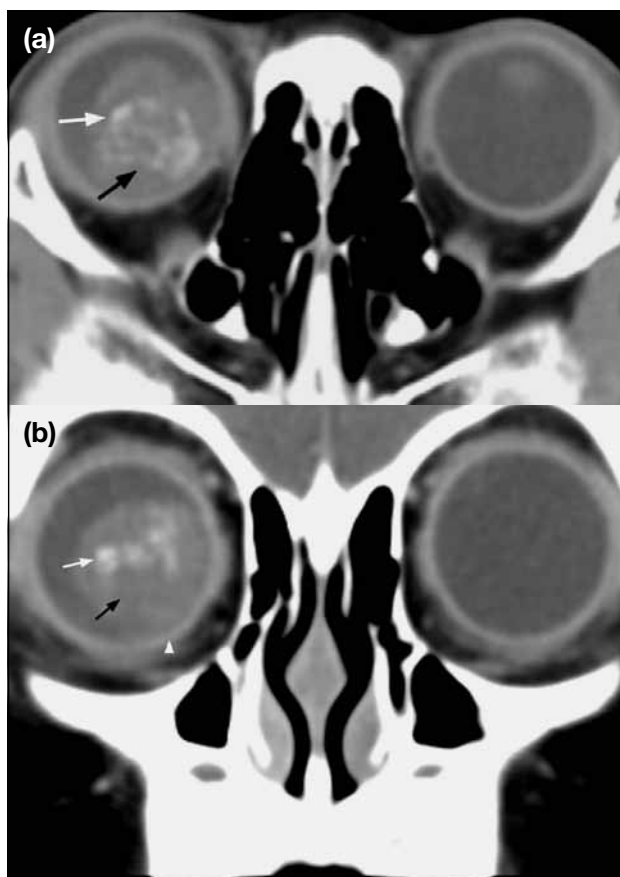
Computed tomographic orbit of a 2-year-old girl with proven retinoblastoma. (a) Axial image: calcified lesion (white arrow) with mass-like enhancement (black arrow). (b) Coronal image: comparable volumes of both affected (white arrowhead) and non-affected globes. Notably there was a calcified lesion (white arrow) with mass-like enhancement (black arrow).
